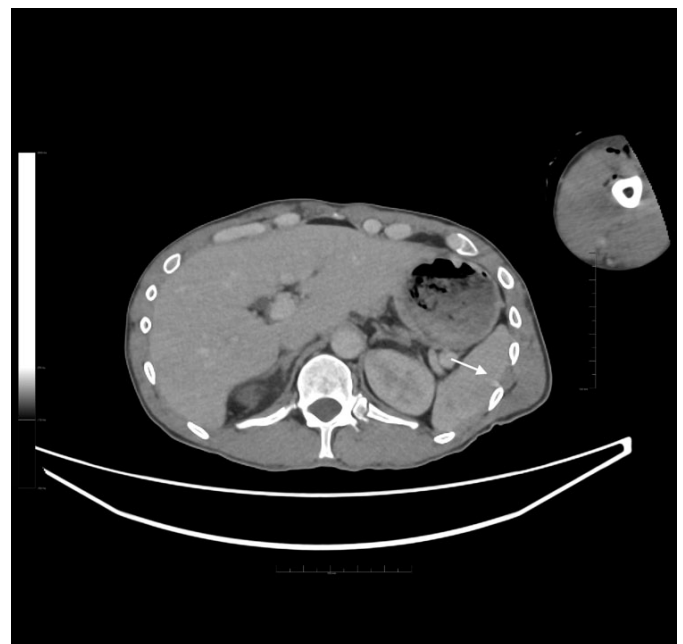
Axial contrast-enhanced CT of the abdomen demonstrating a Grade 2 splenic injury (AAST classification) (white arrow).
